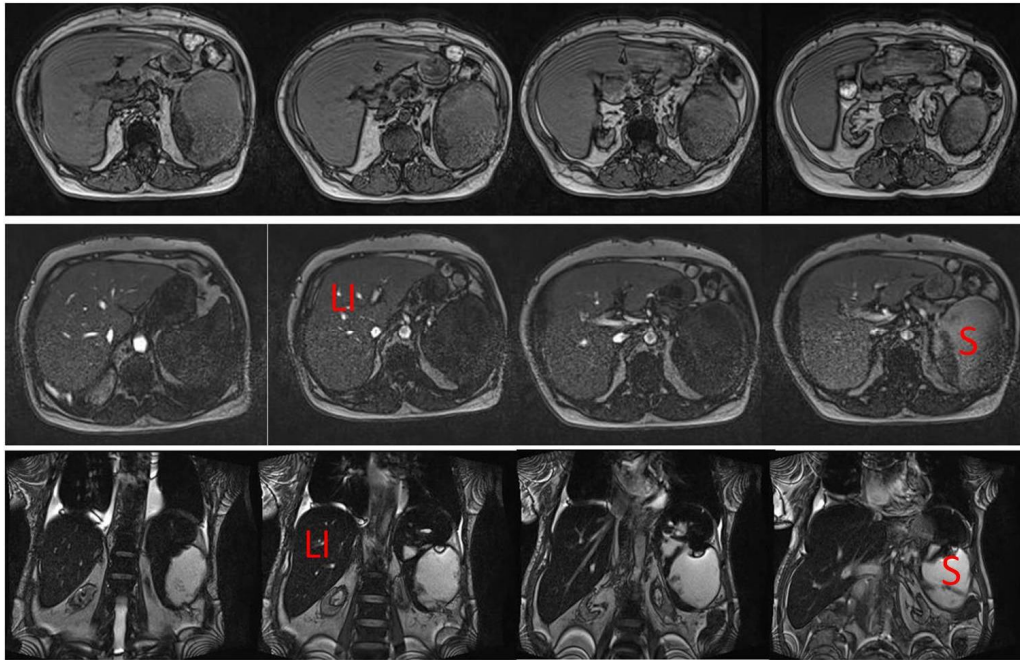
Axial and coronal non-contrast MRI images of the abdominal region revealing atherosclerosis with splenic infarction. S: spleen; LI: liver.
